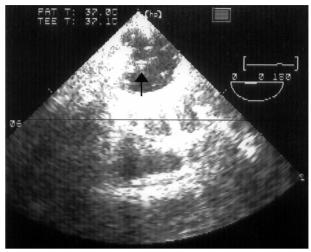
Transesophageal transverse image of descending thoracic aorta demonstrates disrupted mobile debris (arrow) seen hanging from aortic luminal surface in the area of balloon inflation.
